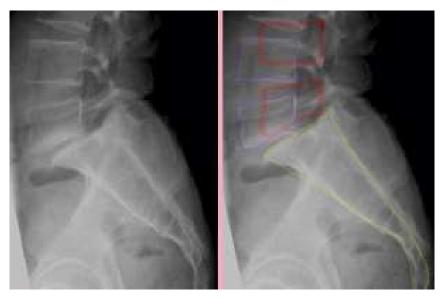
At left is a lateral x-ray showing an anterolisthesis at the L5-S1 level. In the annotation at right, the sacrum is outlined in yellow and the lumbar vertebral bodies in purple. The faint red lines outline the correct anatomic position from which the lumbar bodies have slipped. (Modified from https://en.wikipedia.org/wiki/Spondylolisthesis#/media/File:SpondylolisthesisL5S1.jpg)
